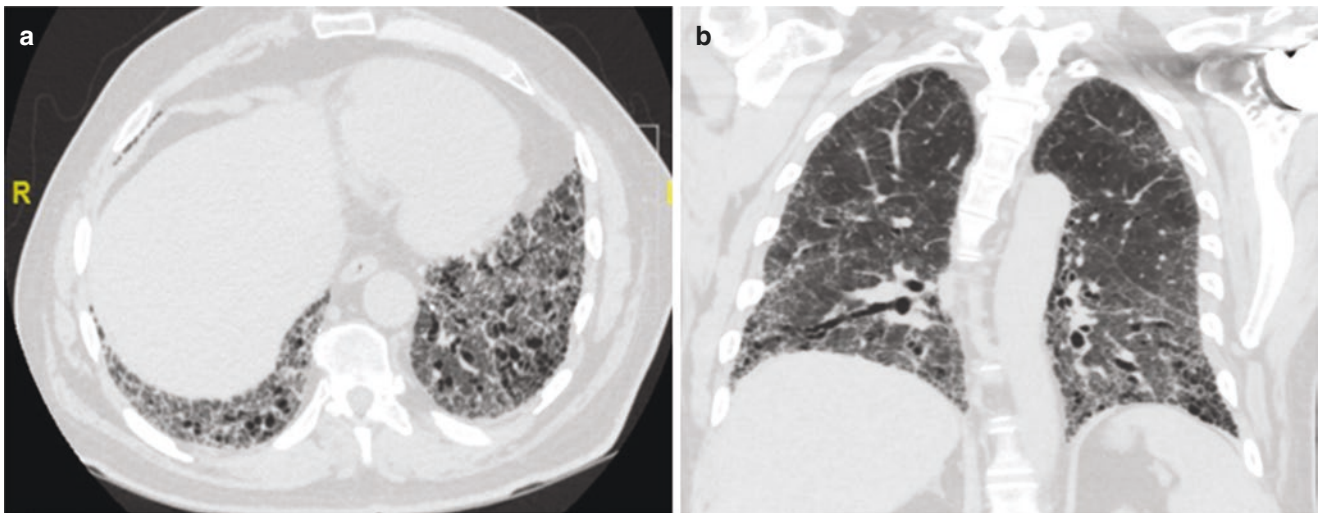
CT demonstrating UIP pattern. (a, b) Features of interstitial fibrosis with honeycombing are seen with predominant involvement of lower lobes. These findings are consistent with a UIP pattern
